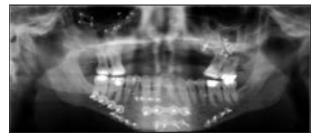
Panoramic radiograph: surgical plates and screws.
